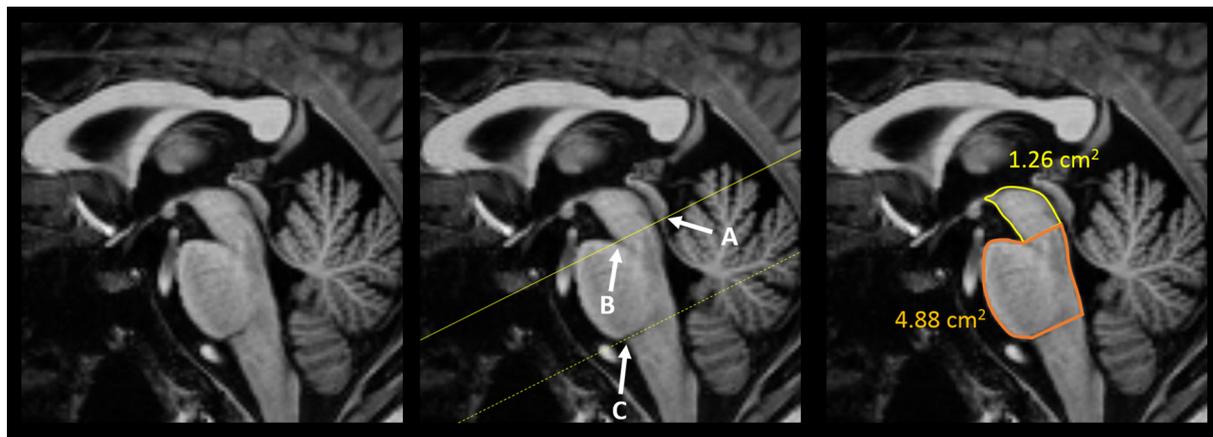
Measurement of the midbrain to pons area ratio. *Left:* Midsagittal plane from a T1-weighted MPRAGE sequence. *Center:* Two overlaid oblique lines. The top line passes through the 2 points of the interpeduncular notch (B) and the inferior margin of the midbrain tectum (A). The bottom line is parallel to the first, passing to the pontomedullary junction (C). *Right:* Segmented areas of the midbrain tegmentum and pons, using the lines from the center figure as boundaries. In this example, the midbrain area is 1.26 cm² and the pontine area is 4.88 cm²; thus, the midbrain to pons area ratio is 0.26. (Images obtained at 7 T using an MP2RAGE sequence.)
